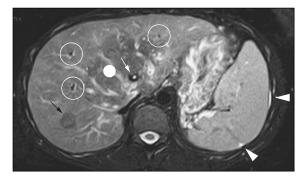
Magnetic resonance imaging of a BCS liver and T2 weighted sequences with fat saturation. Segment I is enlarged. The central area of the liver (white dot) presents with a typical aspect of lower signal intensity in comparison with the peripheral areas. The 3 major hepatic veins (white circles) appear as hypointense fibrous cords. There is a patent TIPS (white arrow). Minimal ascites (white arrow heads). A macronodule resembling focal nodular hyperplasia is seen (black arrow).
